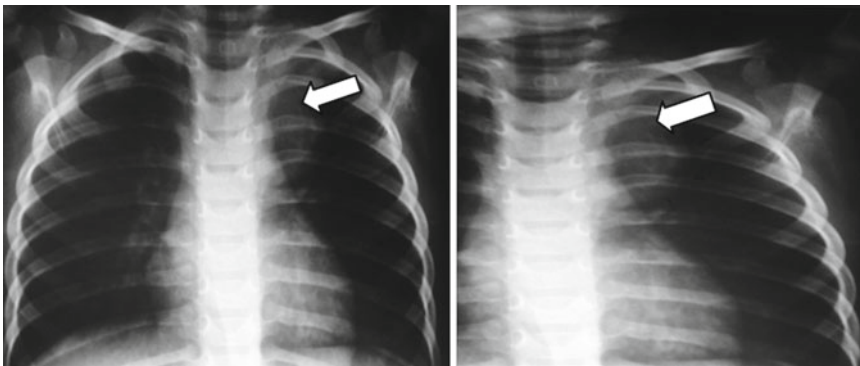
Mediastinal tumors may results in respiratory distress, although those found in the lower mediastinum may be asymptomatic and discovered incidentally on routine radiographs obtained for unassociated medical reasons
